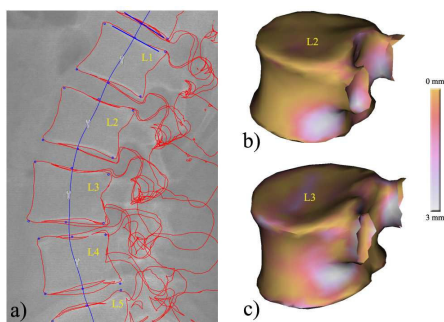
(a) Projection of the silhouette of the 3D reconstruction of vertebrae (L1 to L5) on a sagittal radiograph of a patient. Reconstruction for L2 (b) and for L3 (c) lumbar vertebra with the distance map of the surface error superposed on the reconstructed model.
